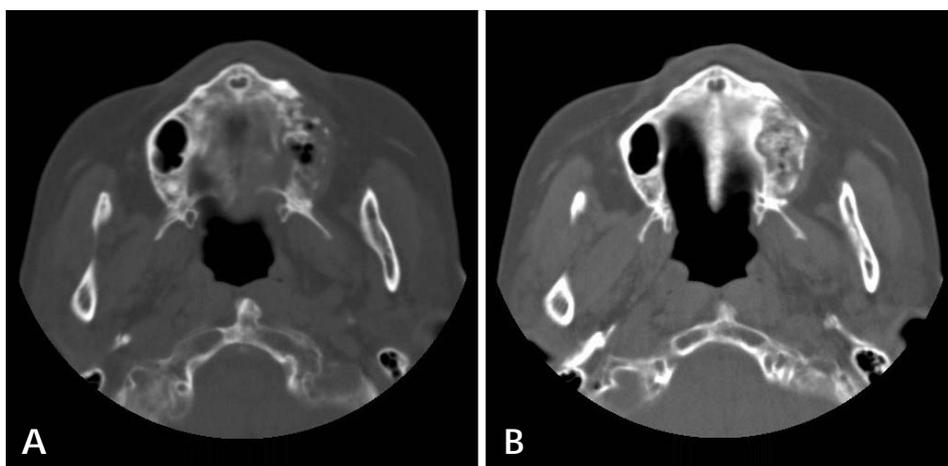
A. Axial CT image reveals cortical bone destruction, sclerotic change of adjacent trabecular bone. B. Axial CT image reveals numerous bony fragments that is considered as sequestrum.
